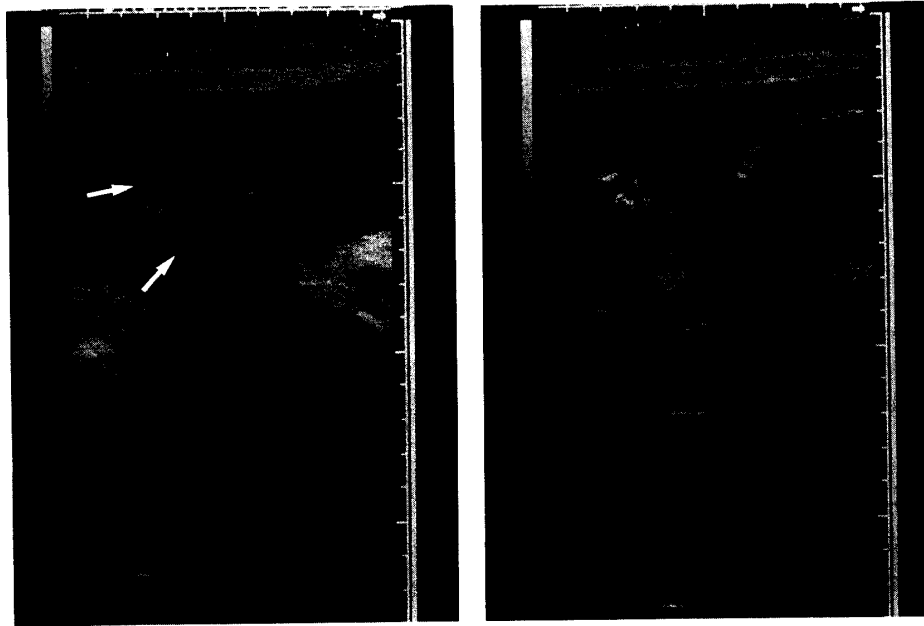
Ultrasonograms of anencephaly diagnosed at 25 weeks of gestation. (Left : transverse view, right : sagittal view) Arrows show the orbita.
